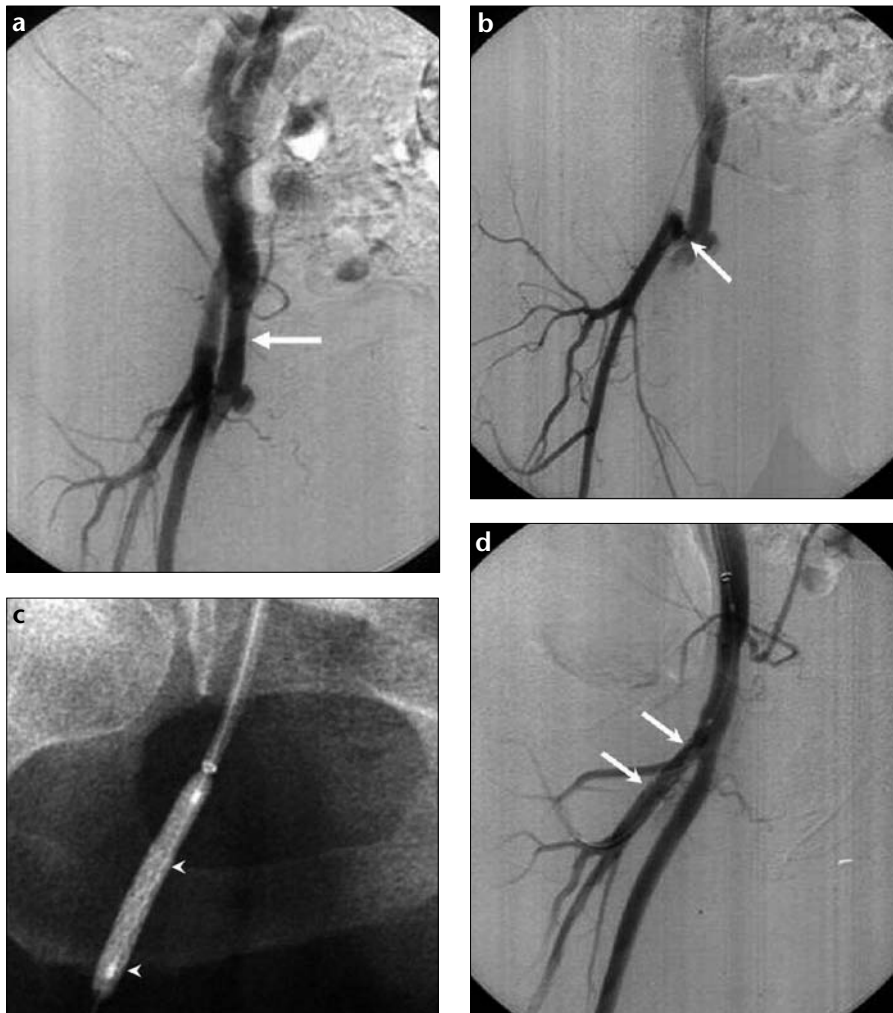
a-d. Cardiac catheterization-induced femoral AVF. a. Right iliofemoral angiogram shows an AVF originating around the femoral artery bifurcation. Note the immediate venous return to the femoral vein (arrow). b. Selective injection into the deep femoral artery reveals that the AVF is between the deep femoral artery and the femoral vein (arrow). c. Native X-ray shows the insertion of a stent-graft (arrowheads) (25 mm long, mounted on a 5.0 mm peripheral balloon) through a 7 Fr flexible guiding sheath by contralateral femoral approach. d. Angiogram after stent-graft (arrows) implantation shows the immediate closure of the fistula.
